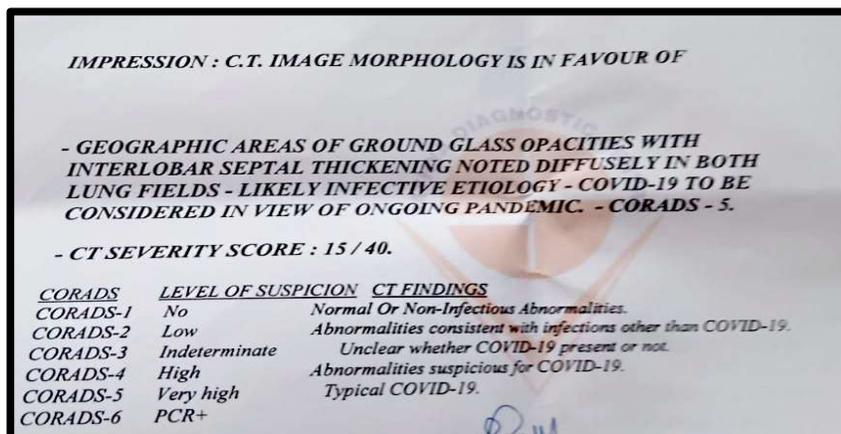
Report of COVID 19 showing CT score as 15/40
